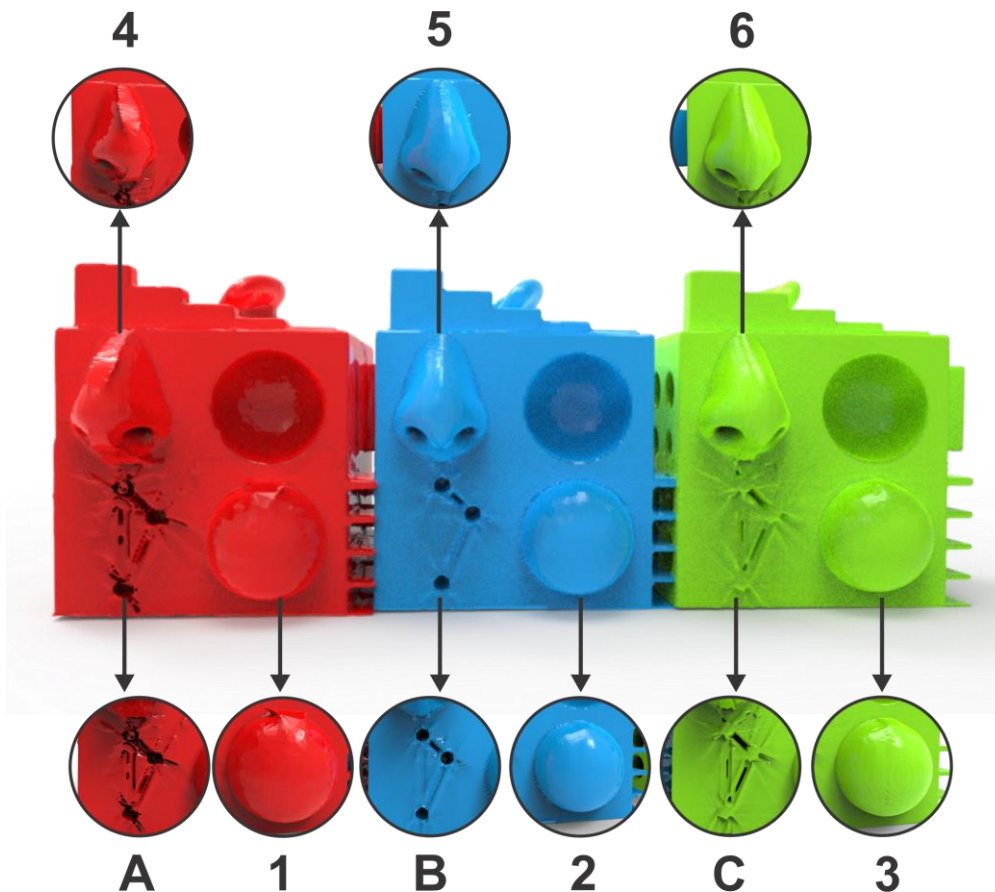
CT results of Anchor Point Test Geometry (A, B, C), Spherical Test Geometry (1, 2, 3), and Anatomical Test Geometries features (4, 5, 6).
